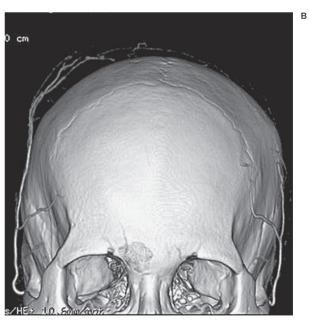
A,B) An initial computed tomography (CT) scan without contrast medium demonstrating a massive subgaleal hematoma (A). In addition, the right superficial temporal artery (STA) that developed is shown by pre-operative CT angiography (B).
